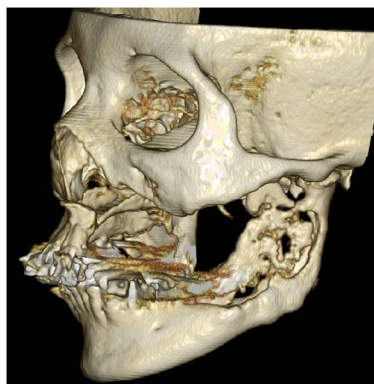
Three-dimensional (3D) computed tomography (CT) imaging findings at the first examination. CT showed a bony sequestrum 45 × 25 mm in size at the site of the mandibular ramus
